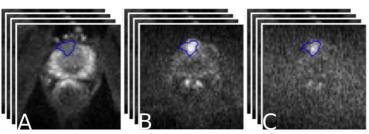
Cancerous regions are seen as a focus of high signal intensity on DW-MRI of  $b=2000,\,3000~\text{s/mm}^2$  (B, C) and  $\,$  as a focus of low signal intensity on  $b=90~\text{s/mm}^2$  .
